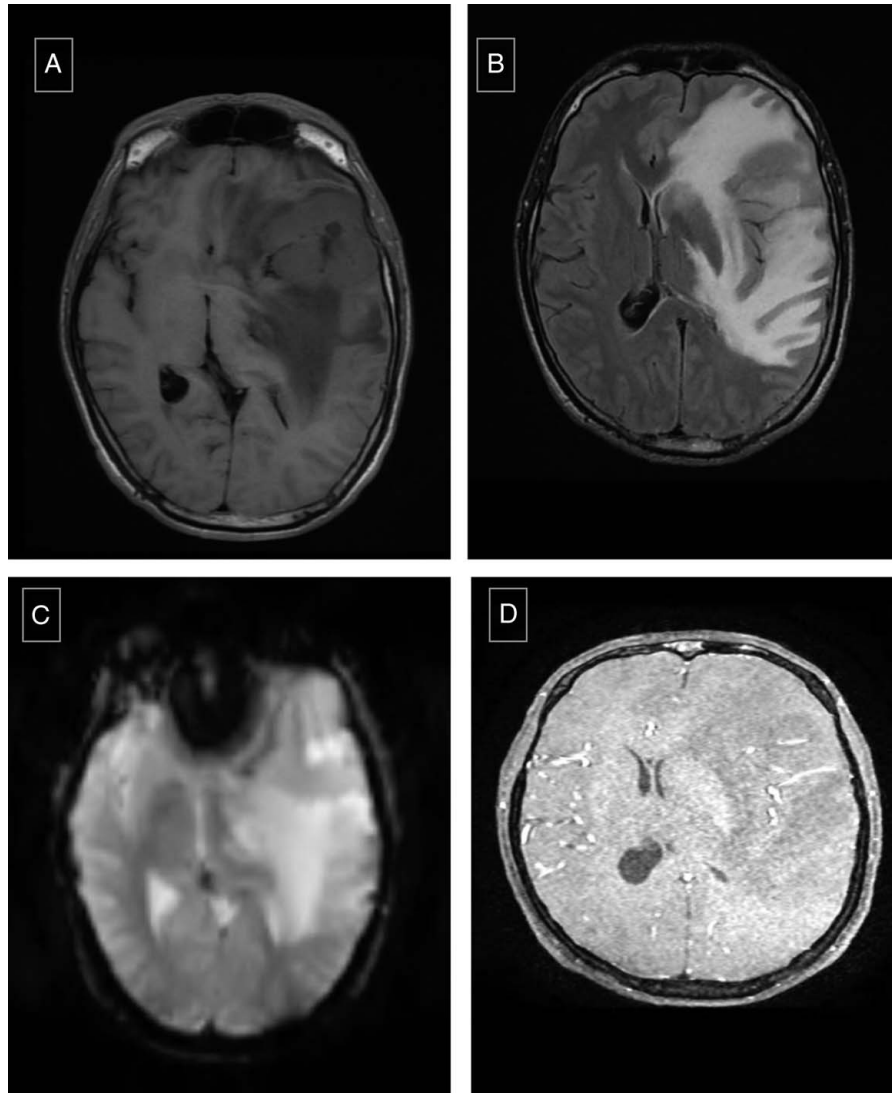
Cerebral MRI shows an extra-axial tumoral process with heterogeneous lobulated contours in T1 hypointense (A), which enhances after injection of gadolinium (D), and in T2 hypersignal (B), and diffusion hypersignal with an ADC measured at 0.6×10^{-9} (C).
